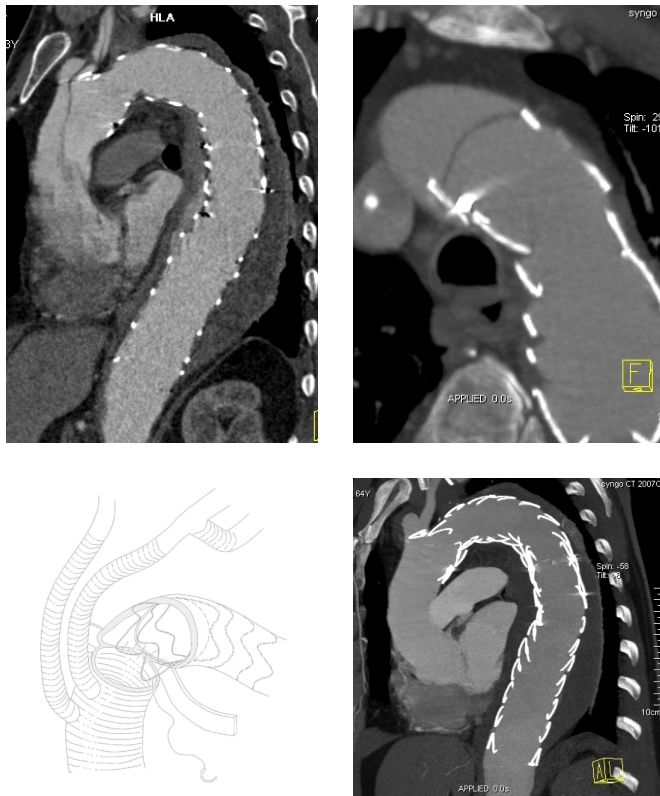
Computed tomography (CT) scan of a retrograde dissection from the proximal part of the endograft (A, B), partial anastomosis of the graft to the previously placed endograft along the alignment with the minor curvature of the arcus aorta (C), and a control CT scan confirming a satisfactory repair (D).
